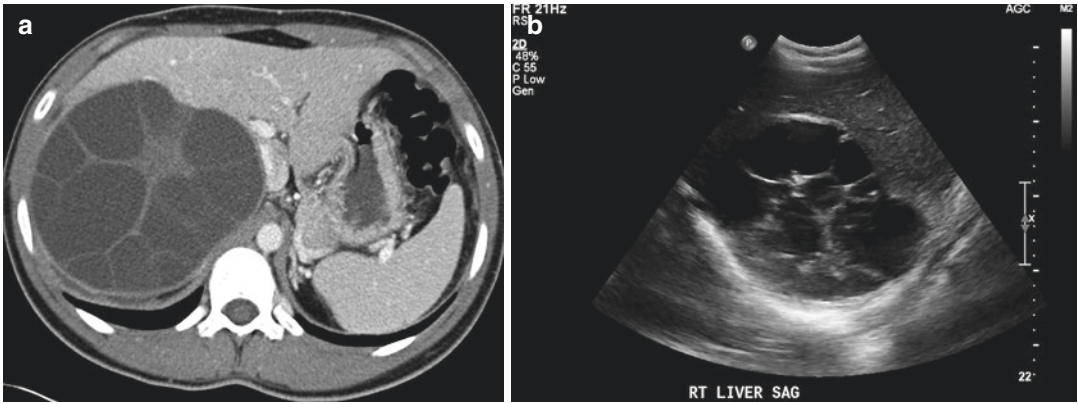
Axial CT image (a) and sagittal ultrasound (b) of the liver of a 19-year-old male with hydatid liver disease. The CT demonstrates a large multiseptated, cystic
